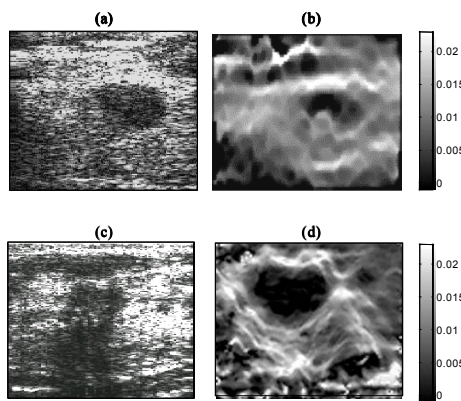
a) Sonogram and b) Elastogram of an in vivo benign breast tumor (fibroadenoma); c) Sonogram and d) Elastogram of an in vivo malignant breast tumor (invasive ductal carcinoma). Grayscale depicts the strain (not in %).
